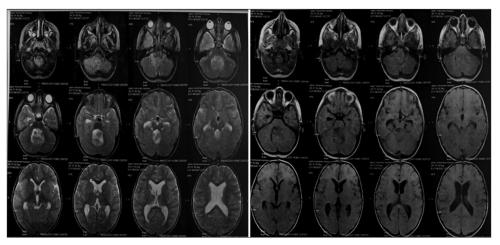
Magnetic resonance imaging of the brain (T1 and T2 images) showing PFBT with supratentorial hydrocephalus.
